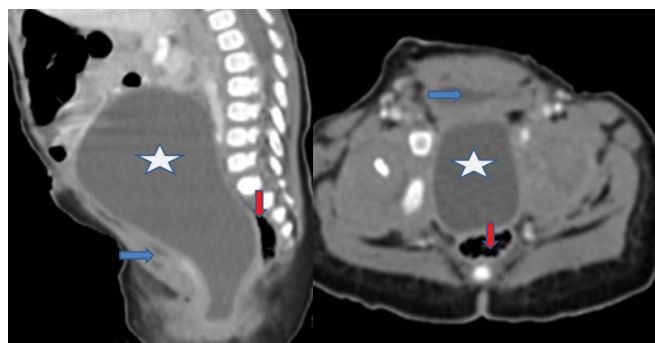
Sagittal and axial CT images of abdomen and pelvis show a large fluid-filled structure (star) conforming to the shape of a uterine cavity between the minimally filled urinary bladder (blue arrow) and compressed rectum (red arrow).
